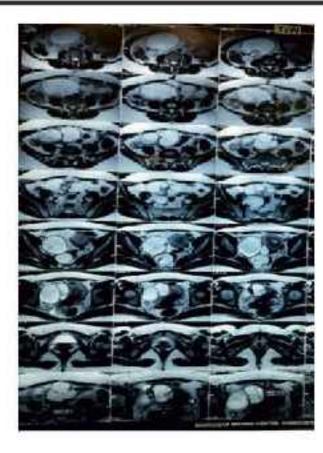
MRI image: large ovarian dermoid cyst of 98 X 55X 225 mm size on right adnexa with right hemorrhagic cyst 22 X 16 mm in size with right cornual fibroid of 18 X 12 mm
